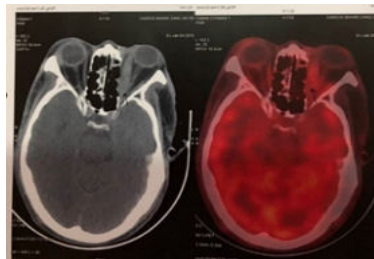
Axial CT scan showing mass in left orbit with thickening of left superior rectus muscle
